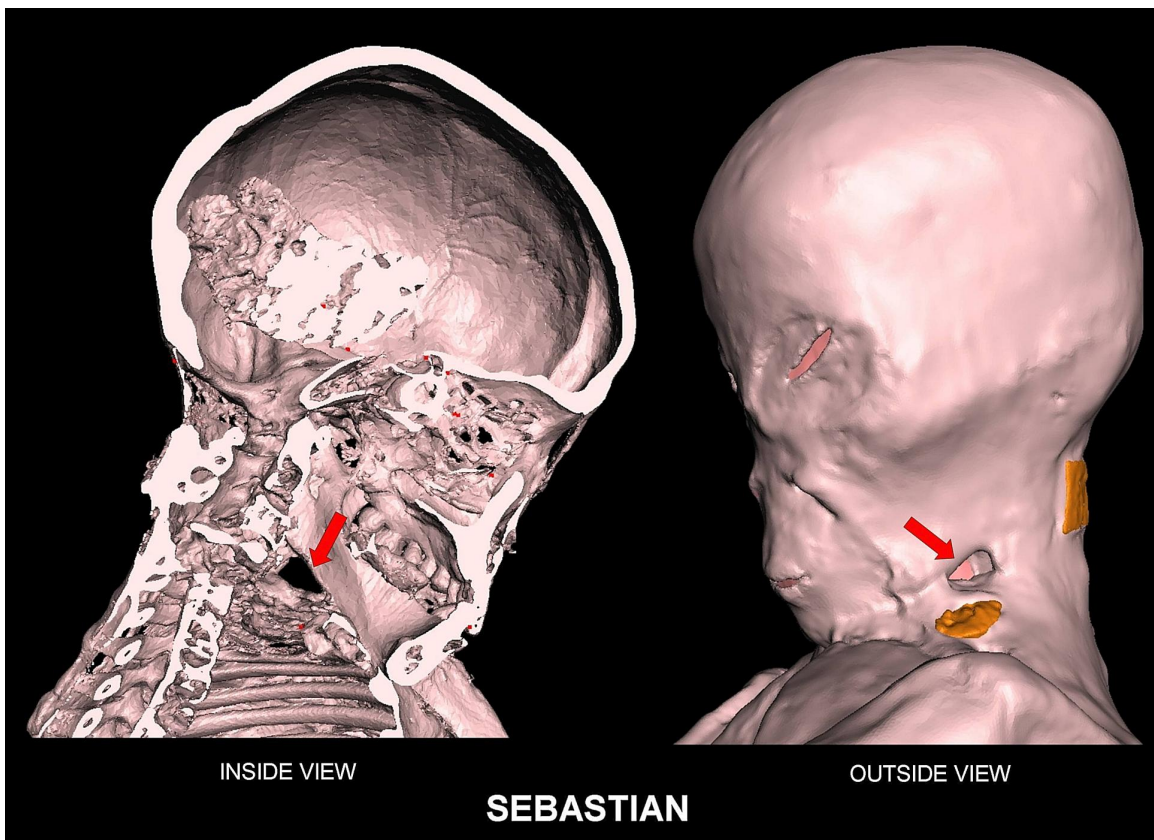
3D CT showing inner (*left*) and outside (*right*) views of triangular shaped large puncture hole (*red arrow*) in left lower neck.
